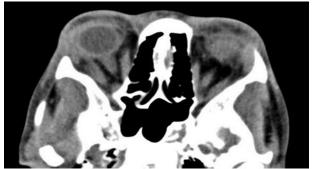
Orbital CT without contrast demonstrating soft tissue swelling
